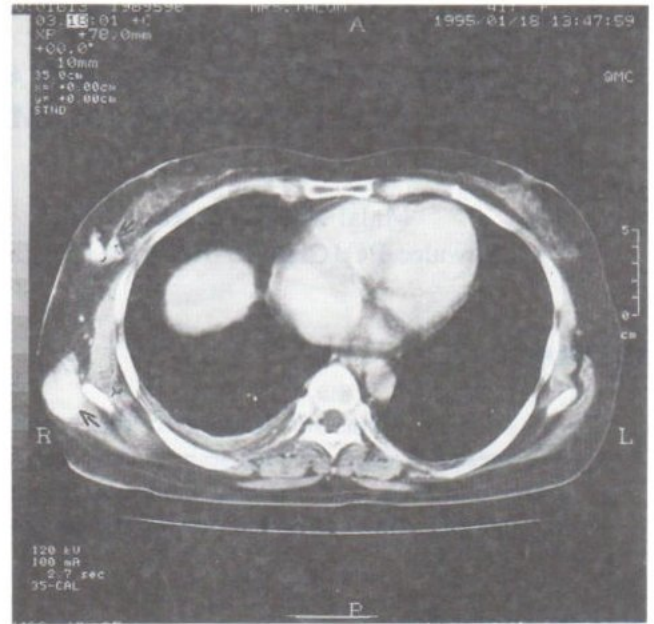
CT scan of the chest showing calcified nodules in the tail of the right breast and subcutaneous tissue (arrows).
